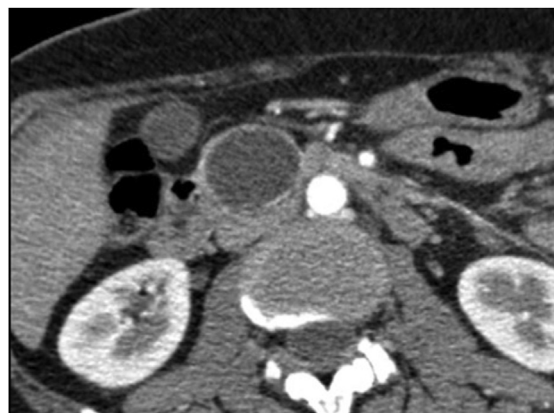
CT findings of a pancreatic head/uncinate cyst.
